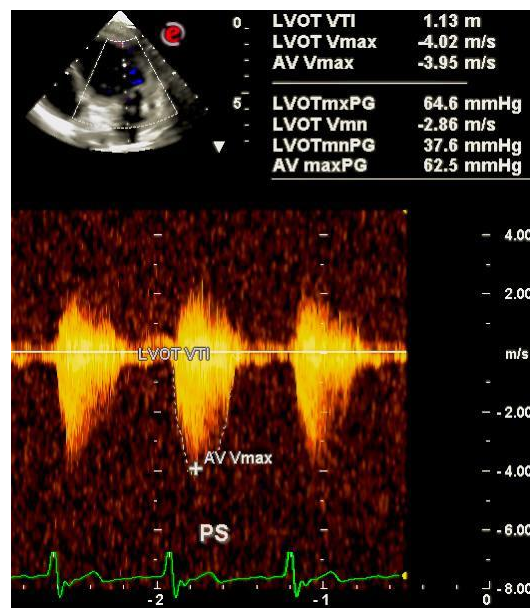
Continuous flow Doppler analysis across pulmonary valve delineates severe pulmonary valvular stenosis with a peak/ mean gradient across pulmonary valve of 64.6/37.6 mmHg.
